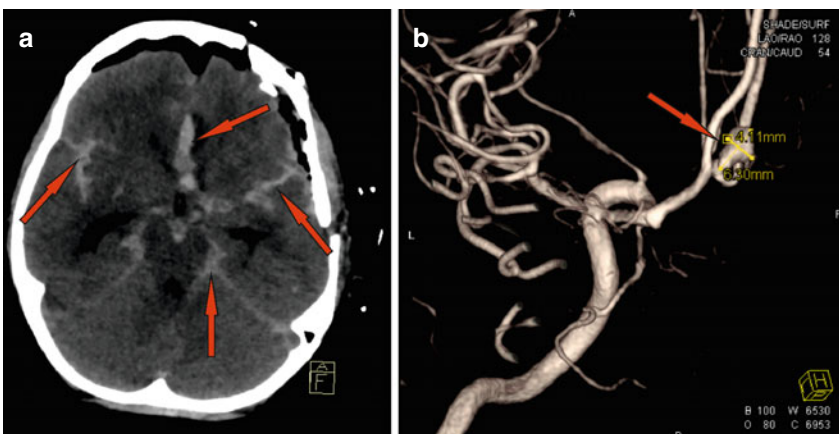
Brain CT imaging demonstrating subarachnoid haemorrhage in the central white area (a) and stretching into the sulci to both sides (red arrows) and after neurosurgical clipping of the saccular-type aneurysm (b)
